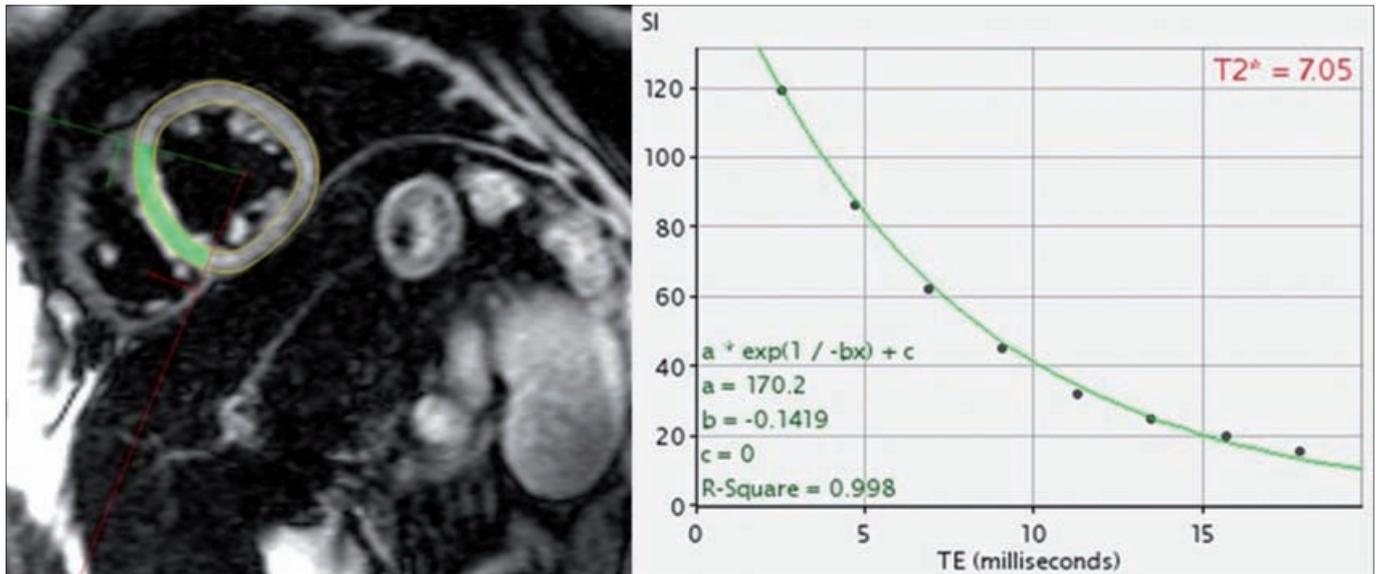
A short axis midventricular cardiac MR image. A full-thickness region of interest was measured in the left ventricular myocardium, encompassing both epicardial and endocardial regions. The T2* value is 7.05 and represents iron overload.
